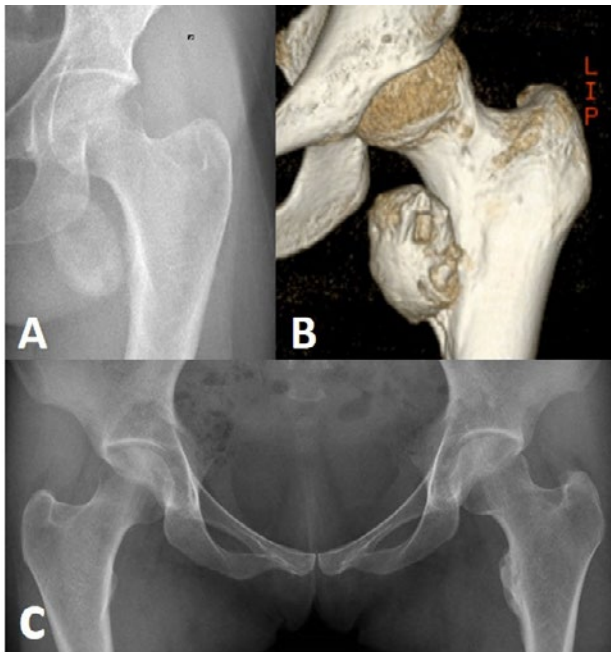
Radiographic examination in AP view and CT scan with 3D reconstruction of the left hip showed a bone mass in the soft tissue around the lesser trochanter (A, B). At follow-up, 9 years after the surgical excision, the radiographic examination of the pelvis did not show any recurrence of the heterotopic ossification (C).
